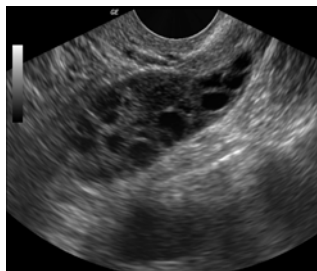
Transvaginal sonogram of the polycystic ovaries showing small cysts scattered throughout the entire ovarian parenchyma.
